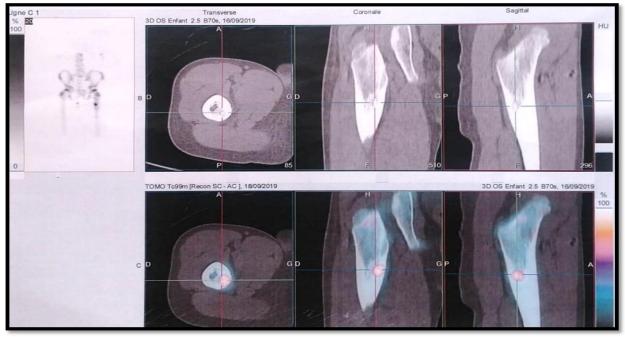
The SPECT CT images show a subperiosteal nidus (Arrows) and cortical thickening.
